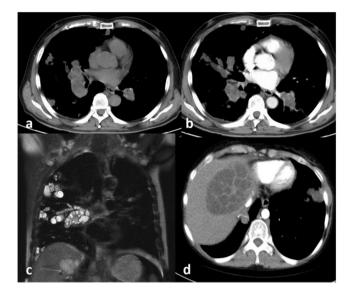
Pulmonary arterial hydatid cyst embolism in a 50-year-old patient with hepatic hydatid. (a) Axial non-contrasted CT shows hypotensive nodules in right lung and aneurysmal expansion of the bilateral lower pulmonary artery; (b) axial CTPA shows multiple cysts fills in bilateral pulmonary artery; (c) coronal T2WI shows hyperintense multiple cystic nodules in the right lung and lower pulmonary arteries; and (d) axial liver contrasted CT reveals typically hydatid liver cyst.
